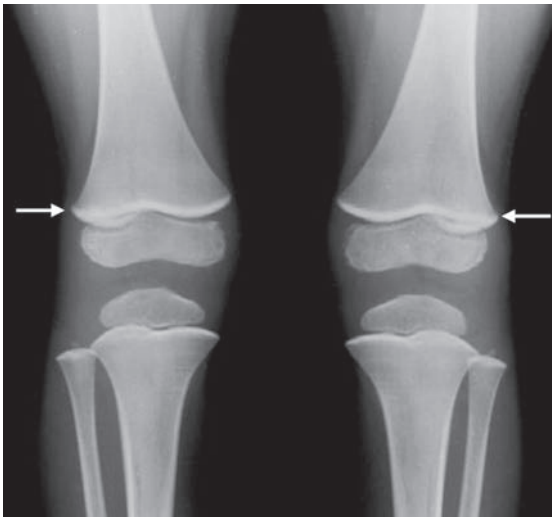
Lead poisoning. AP radiograph of the knees reveals transverse bands of increased density in the metaphyses of the long bones (arrows)
